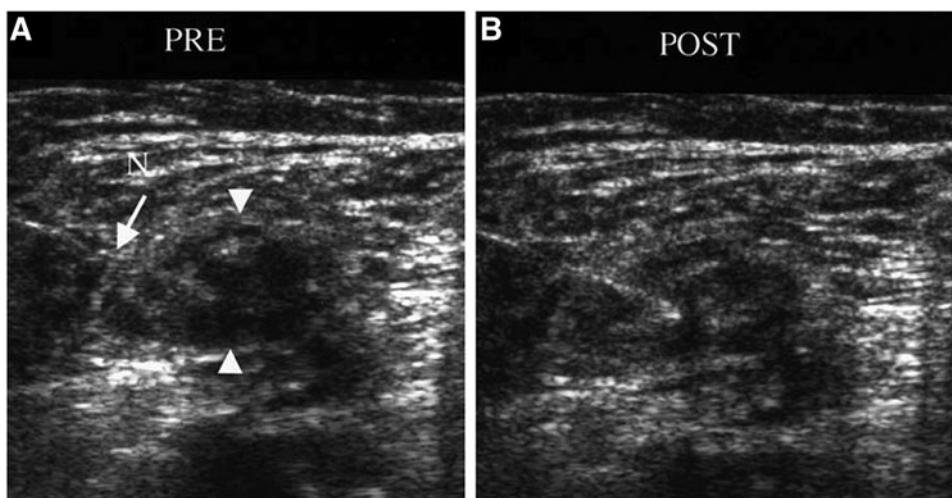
Ultrasound imaging of a neuroma with the needle in position (A) before and (B) after anesthetic steroid injection (arrowheads represent location of neuroma; arrow denotes location of needle). (B) After the injection, increased echogenicity is noticed within the neuroma, demonstrating effective delivery of the steroid anesthetic. Reprinted with permission from Ernberg *et al.*⁸ N, needle.
